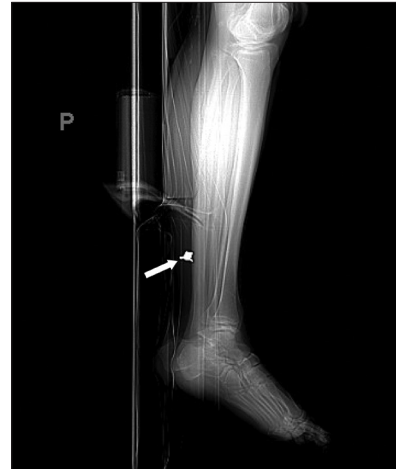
Computed tomography of the right lower extremity. The white arrow demonstrates the bullet fragment in the right distal lower extremity.
